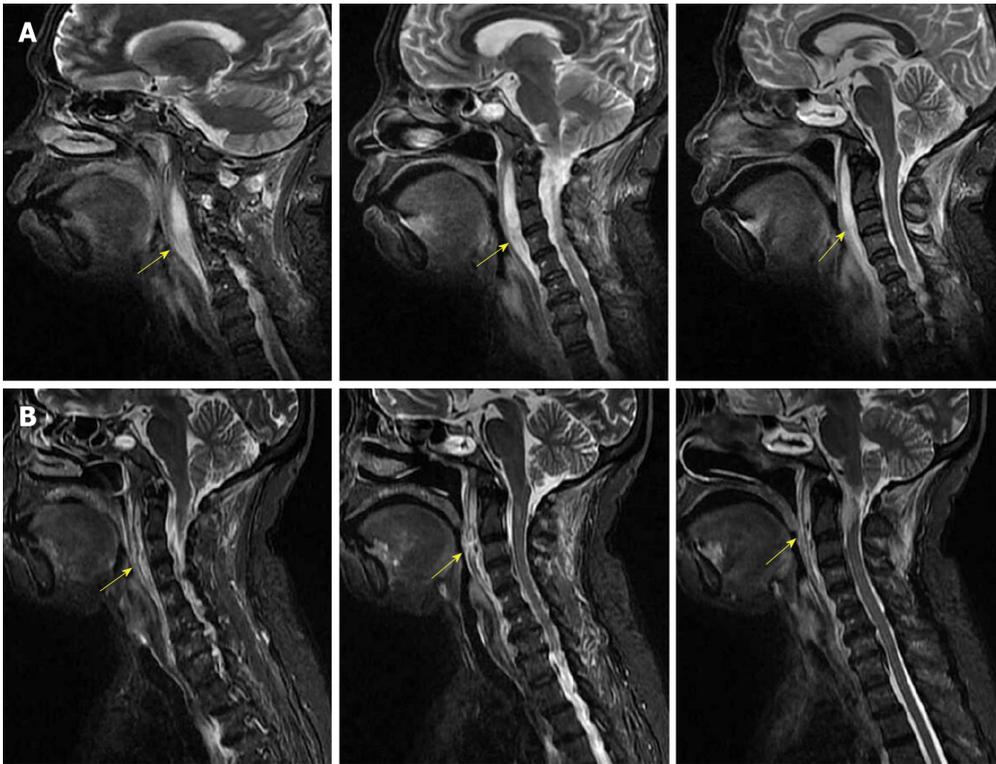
MRI findings. A: Contrast-enhanced MRI shows the retropharyngeal abscess and obvious upper airway stenosis (yellow arrow); B: MRI suggests that upper airway stenosis was significantly alleviated after surgery (yellow arrow). MRI: Magnetic resonance imaging.
